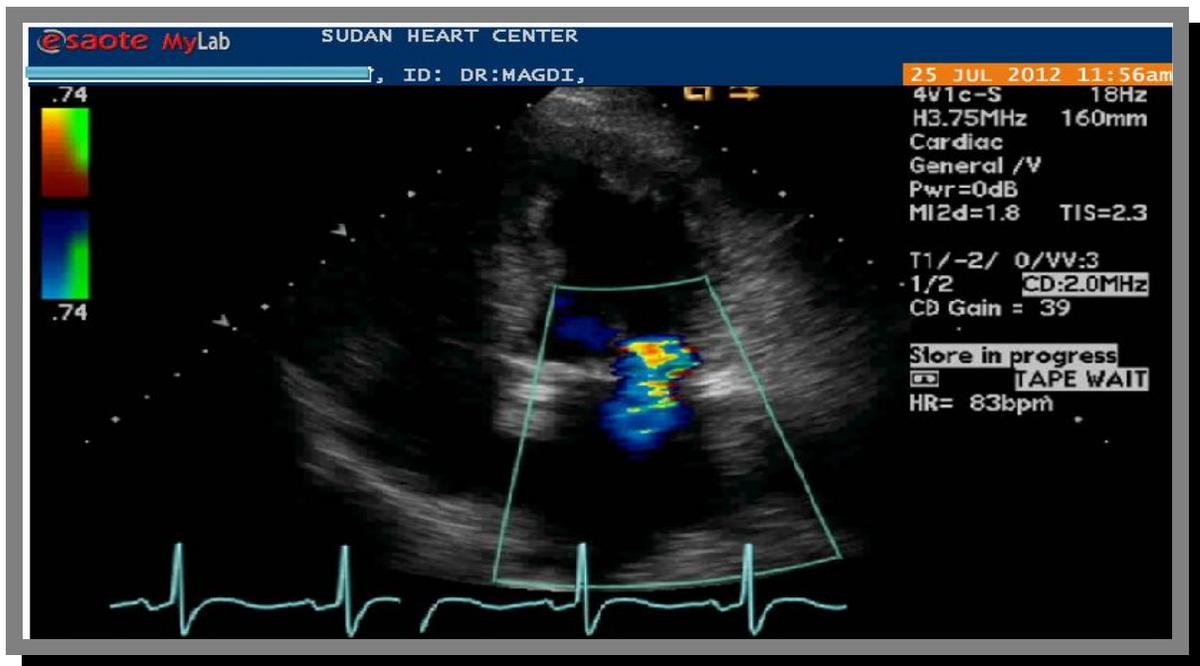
Use of color Doppler shows the presence of tricuspid valve (left) and mitral valve (right) regurgitation.
